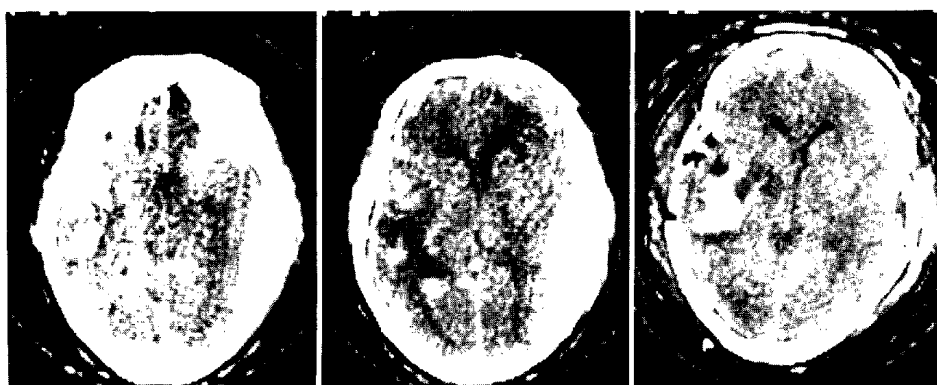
Epidural hematoma and intracerebral hematoma. 31-year-old male. A subdural hematoma on the right side and several small hemorrhages in the left temporal lobe, which were considered as a contusion at this stage, can be seen on CT, examined 14 hours after trauma (left, middle). As an emergency operation, removal of the epidural hematoma on the right side and external decompression on the left side, were performed. CT taken a day after the operation revealed that the intracerebral hematoma became larger than when previously examined (right).
